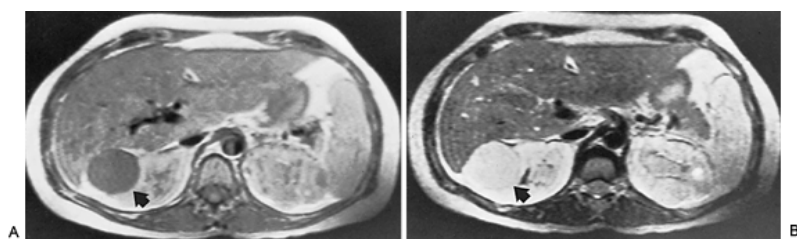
Simple cyst in a 44-year-old woman. A: Magnetic resonance imaging of a T₁-weighted image is characteristic of a simple right renal cyst (*arrow*) because of the distinct smooth margin and because of the low signal intensity (e.g., the cyst contents are very black). B: To confirm the diagnosis of a simple cyst, a T₂-weighted image demonstrates the cyst contents to have a high signal intensity (e.g., to be very white), which is consistent with water.
